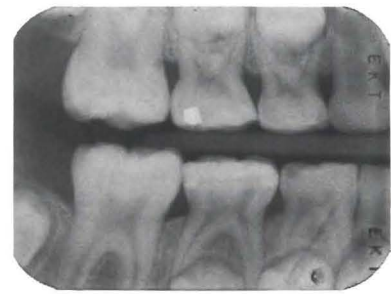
Nine-months postoperative radiograph of the restoration shown in 18A.
